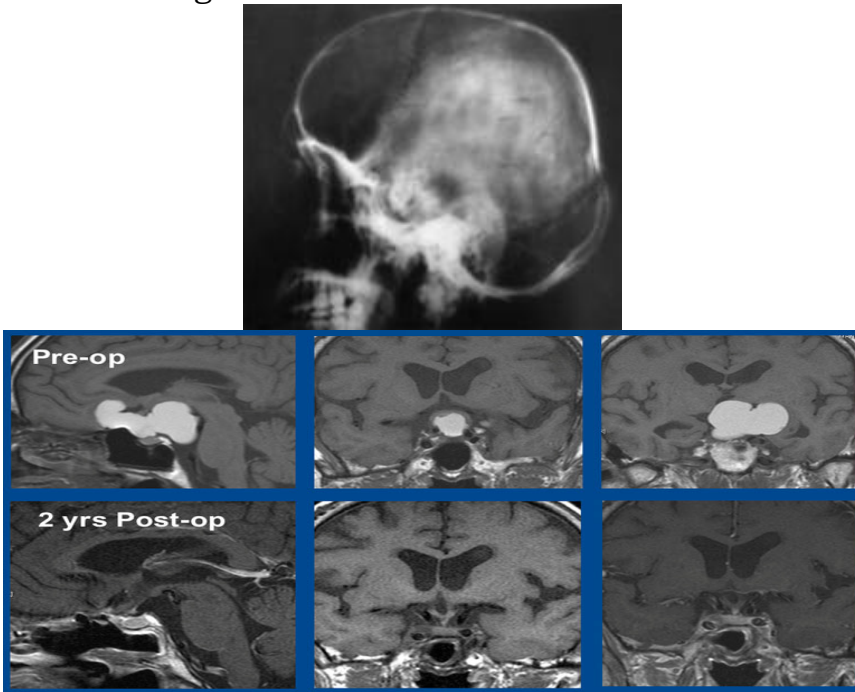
Pituitary/hypothalamic imaging: initial plain film showing previously undiagnosed craniopharyngioma calcifications on left; three preoperative non-calcified pituitary tumor views on the upper panel and then the same patient 2 years postoperatively with similar comparative views
